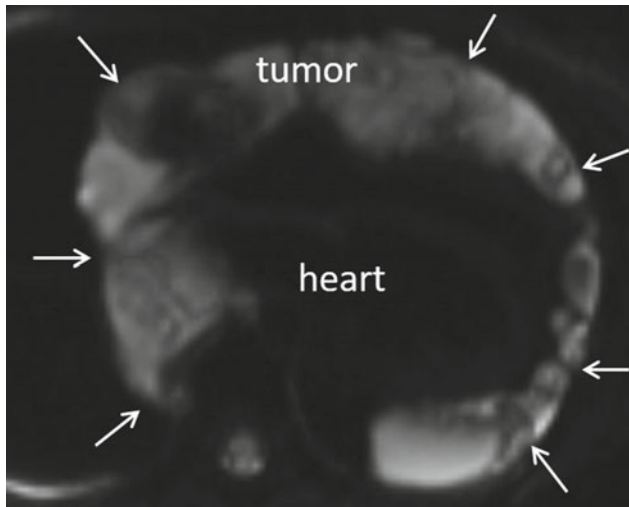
Chest MRI (diffusion weighted imaging) of the patient demonstrating the tumor embracing the heart and great vessels
